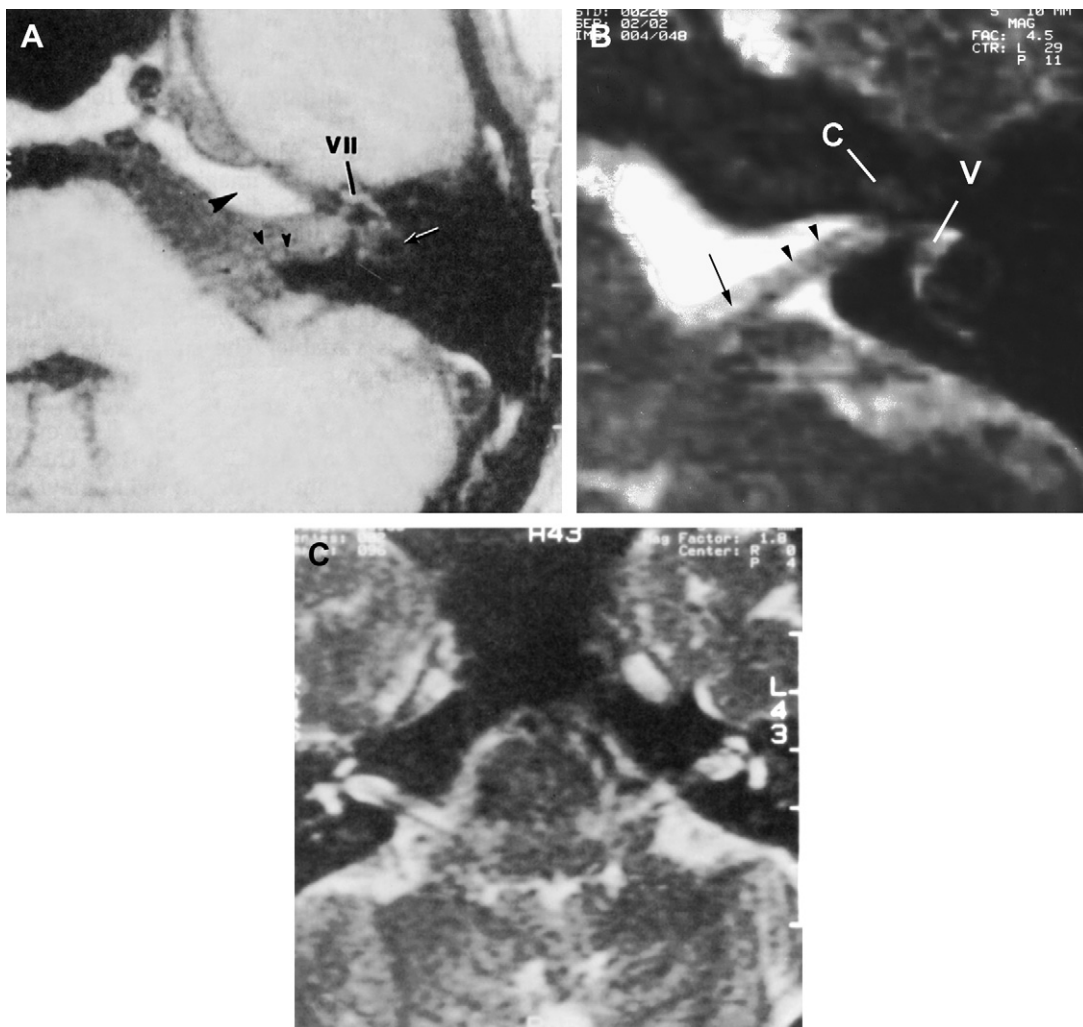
(A) T₁-weighted (TR 600/TE 20) magnetic resonance image of the temporal bones. There is enough signal from the soft tissue of the facial nerve (VII) and the fluid in the internal auditory canal (IAC) as well as in the horizontal semicircular canal (*arrow*) to allow visualization contrasted against the mastoid and otic capsule. Note that the fluid and soft tissue signal is not nearly as bright as the fat (*large arrowhead*) in the petrous apex. *Small arrowheads* indicate neural elements. (B) T₂-weighted image (TR 2500/TE 90) turns the cerebrospinal fluid and the fluid in the vestibule (V) bright white. The intermediate signal from the cochlea (C) does not indicate that there is tissue within but rather that there is partial volume effect. The bright fluid in the cochlea is averaged with the contiguous bone to give an intermediate signal intensity. Nerve elements in the IAC (*arrowheads*) are extending from the root exit zone at the pontomedullary junction (*arrow*). (C) Extreme T₂-weighted image (TR 4000/TE 120) shows the bright signal in the cochlea, the vestibules, and IAC. On the right side a nerve can be seen from the pontomedullary junction to the fundus of the IAC.
